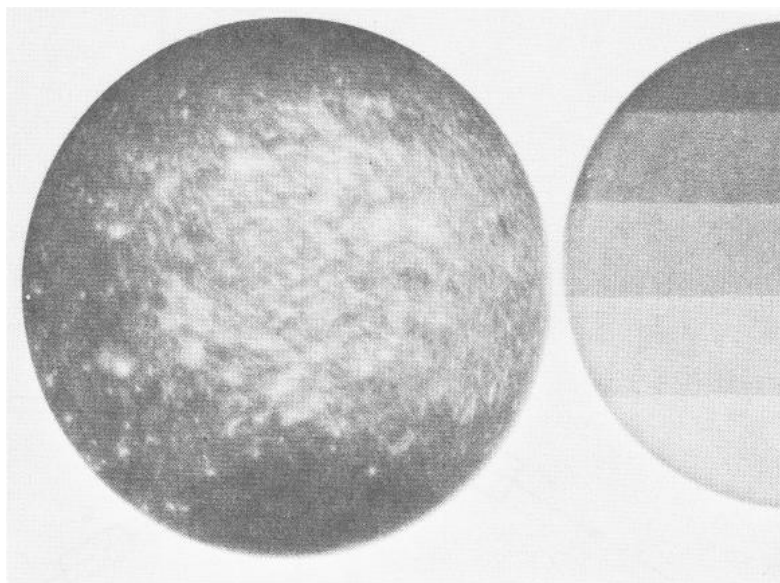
Proton radiograph of Grade AUC graphite 7.62 cm diameter, 9.2 gm/cm² thick. Portion of aluminum stepwedge, having steps of 0.05 gm/cm², provides calibration. Variation of graphite density is about 3 percent peak to peak.
